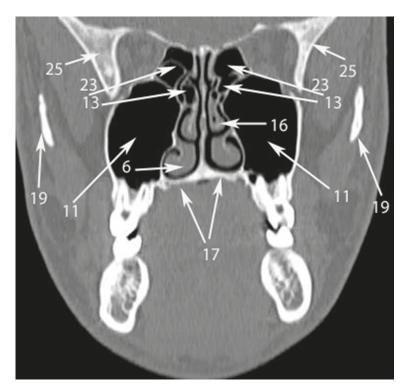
Coronal CT scan at the level of 1st molars. *Numbers* with *arrows* denote the following anatomical structures: 6 – inferior nasal concha; 11 – maxillary sinus; 13 – ethmoidal air cells (Latin: cellulae ethmoidalis); 16 – middle nasal concha; 17 – hard palate (palatine process of the maxilla); 19 – zygomatic bone; 21 – zygomatic process of the frontal bone; 23 – sphenoid sinus; 25 – greater wing of the sphenoid bone.
